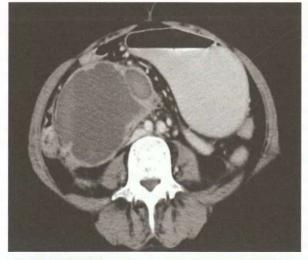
Retroperitoneal haematoma contrast CT
